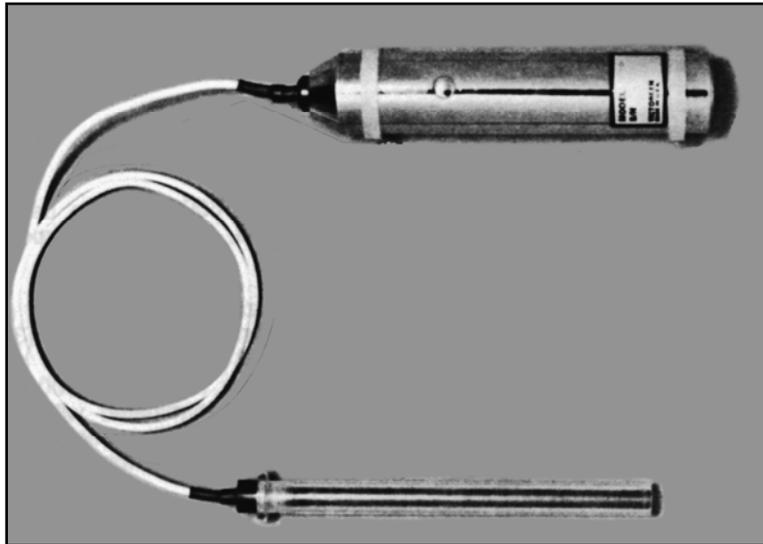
Model 660-6 and Model 500-100 CT Probes
